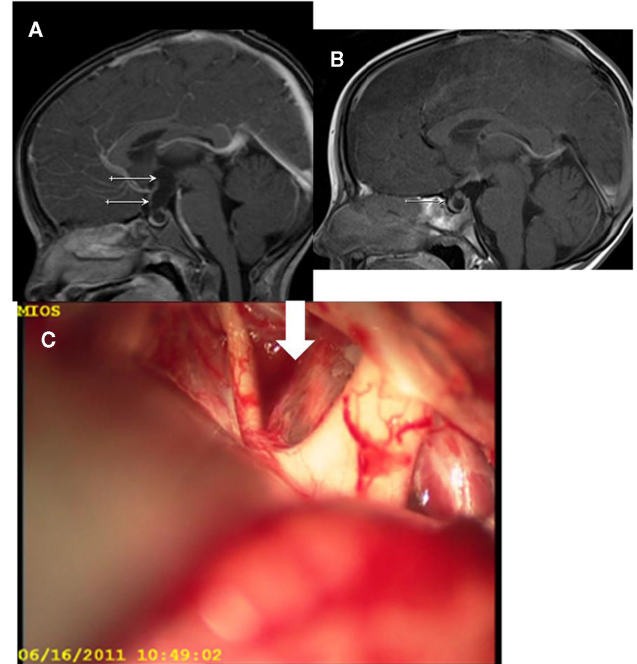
Sagittal MRI of a child with an intra- and suprasellar craniopharyngioma reaching the optic nerves (Type 1). Special attention has to be given to the partial pneumatization of the sphenoid sinus, since the thick bone has to be drilled during the access to the sella. This can cause problems in orientation for the surgeon and endanger the carotid arteries, which may be solved by the use of a microdoppler and/or neuronavigation.
